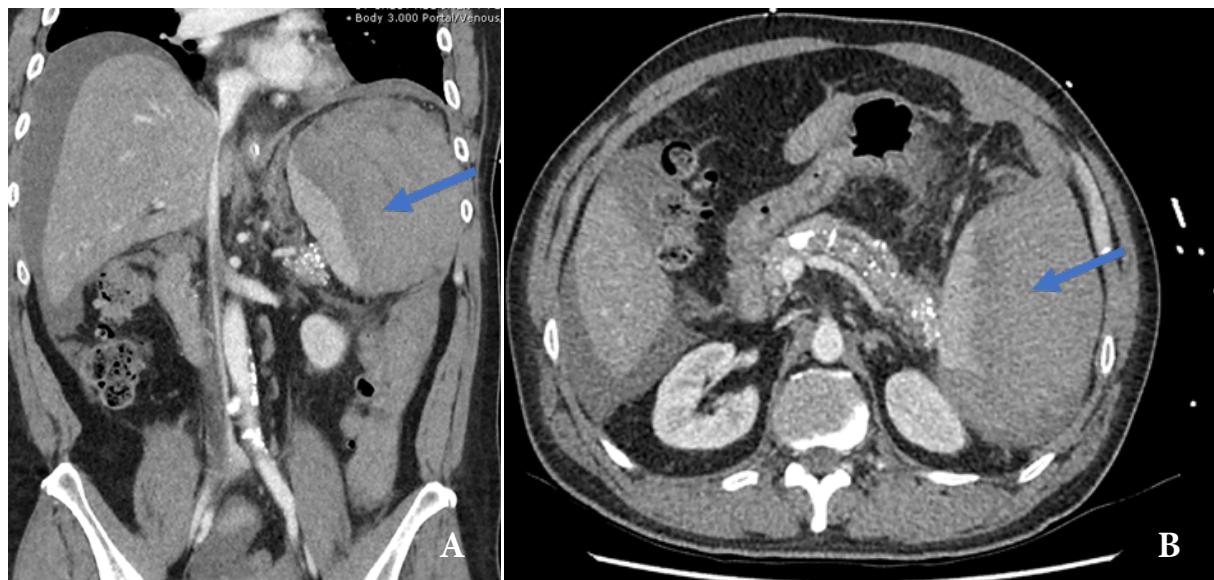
Computed tomographic image (A. coronal and B. axial views) in the portovenous phase demonstrating the splenic hematoma (arrow) with hemoperitoneum.
